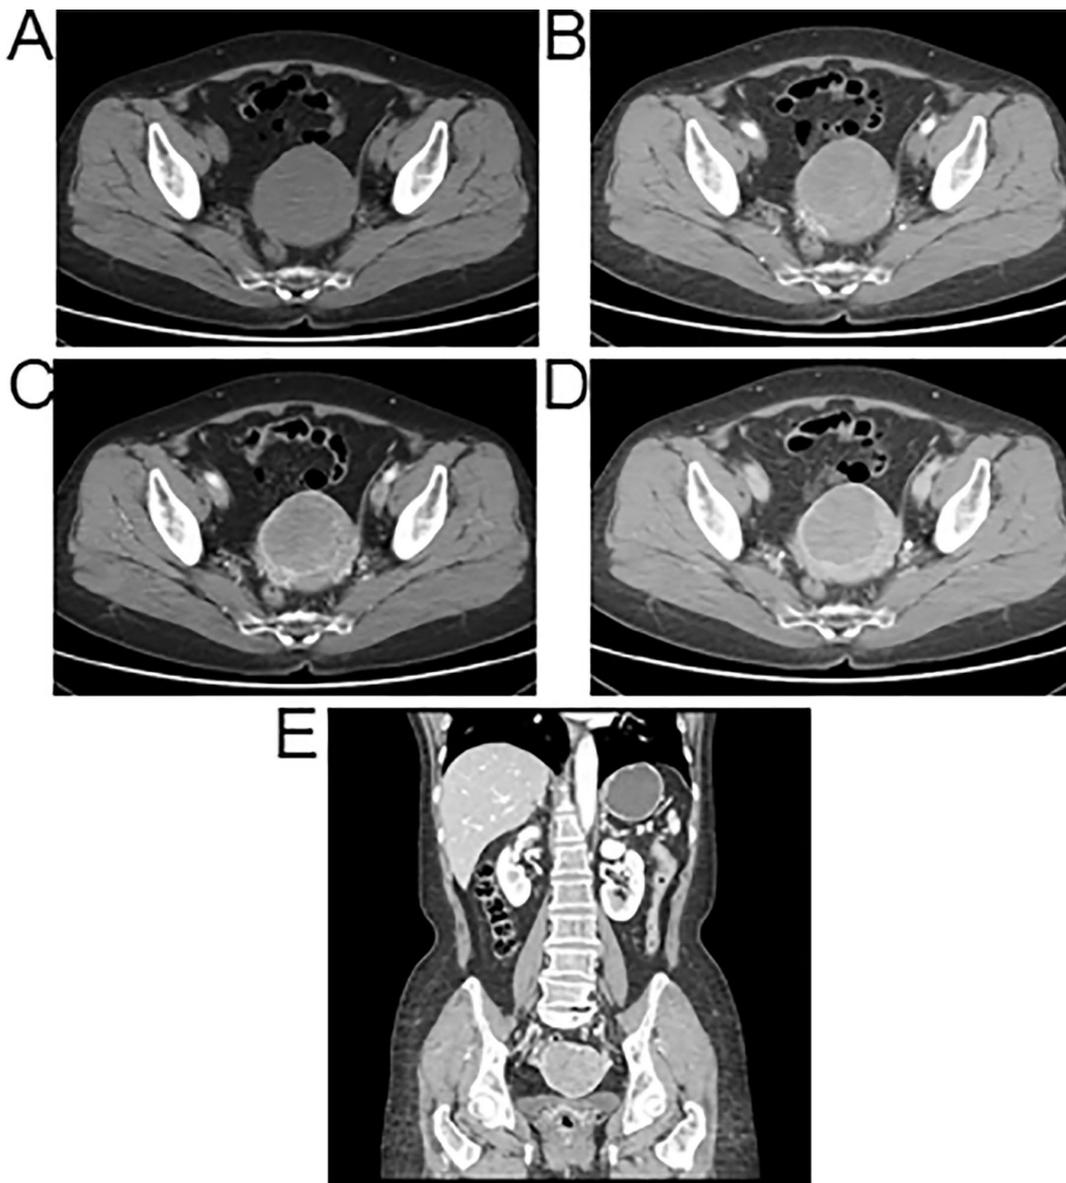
Abdominopelvic computed tomography (CT) findings. The CT shows a pelvic mass with a hypodense lesion (approximately 5.5 cm) in the uterus. (A) Pre-contrast image. (B) Arterial phase image. (C) Portal phase image. (D) Delayed phase image. (E) Sagittal plane image.
